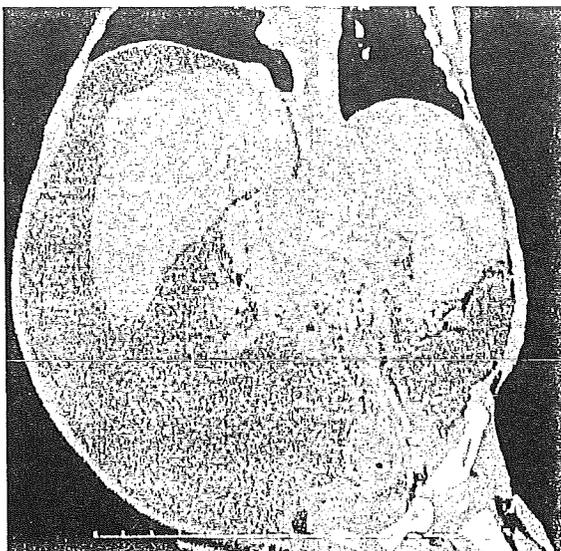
CT demonstrated the tumor in the liver at segment 8 with massive ascites.
